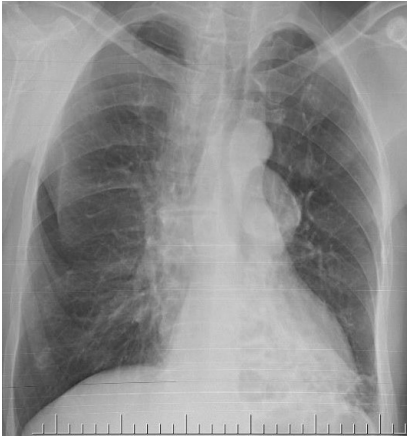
Chest radiograph opacity in the left hilar region
